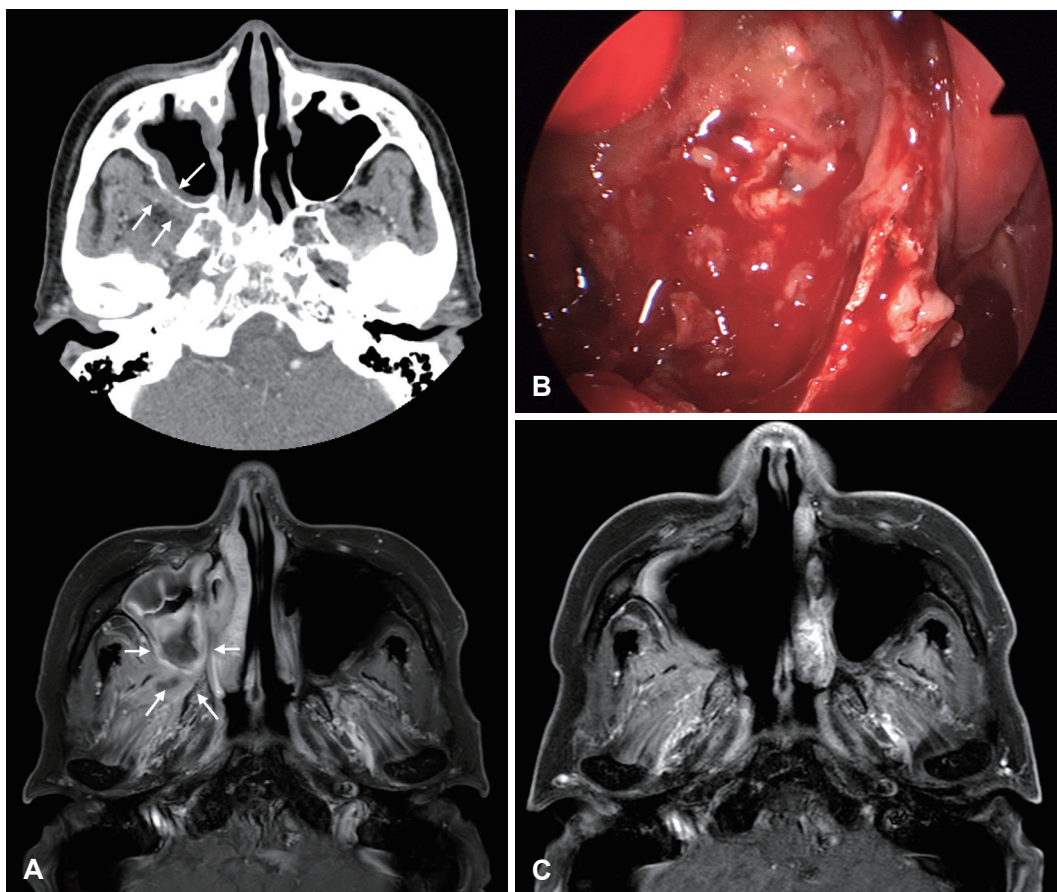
Gadolinium (Gd)-enhanced MR images and intraoperative finding of a patient with acute invasive fungal sinusitis. A: Loss of contrast enhancement (LoCE) was preoperatively identified in the right maxillary sinus and retroantral area (arrow). B: Necrotic tissue in the posterior wall of the maxillary sinus and retroantral area was completely resected via endoscopic medial maxillectomy approach. C: Postoperative Gd-enhanced MR image showed no remnant LoCE lesions, and the patient was successfully treated with surgical debridement and antifungal therapy.
